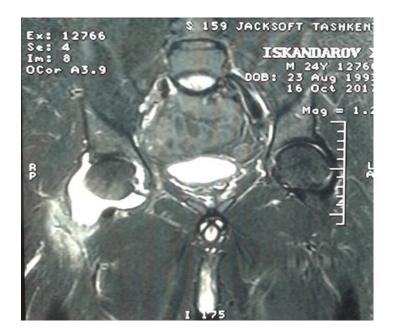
MRI scan of the pelvic bones (before surgery)
